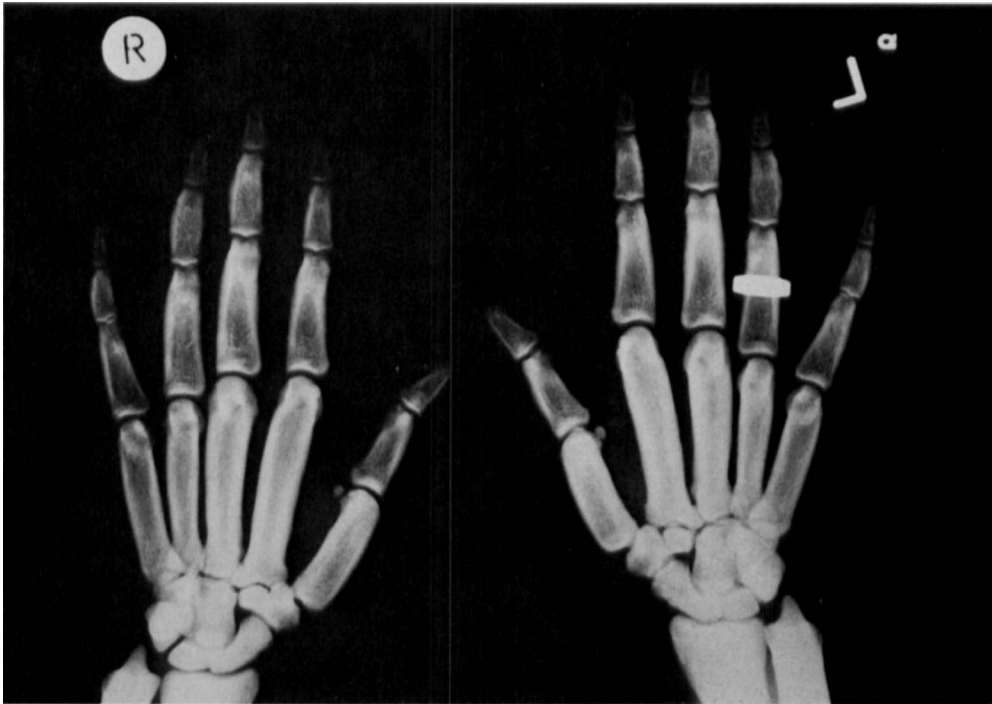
Sclerosteosis: Hand radiograph of an adult female showing changes similar to those in Fig. 6. Soft tissue syndactyly is present in patient.
